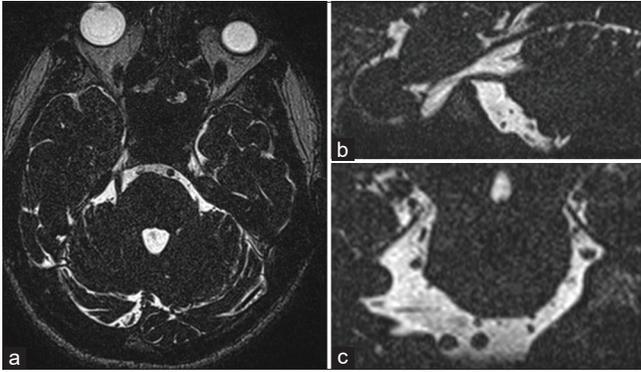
Preoperative MRI at the level of the cisternal part of the trigeminal nerves in CISS sequence. (a) Axial plane. (b) Sagittal plane. (c) Coronal plane. MRI demonstrates no signs of vascular conflict.
